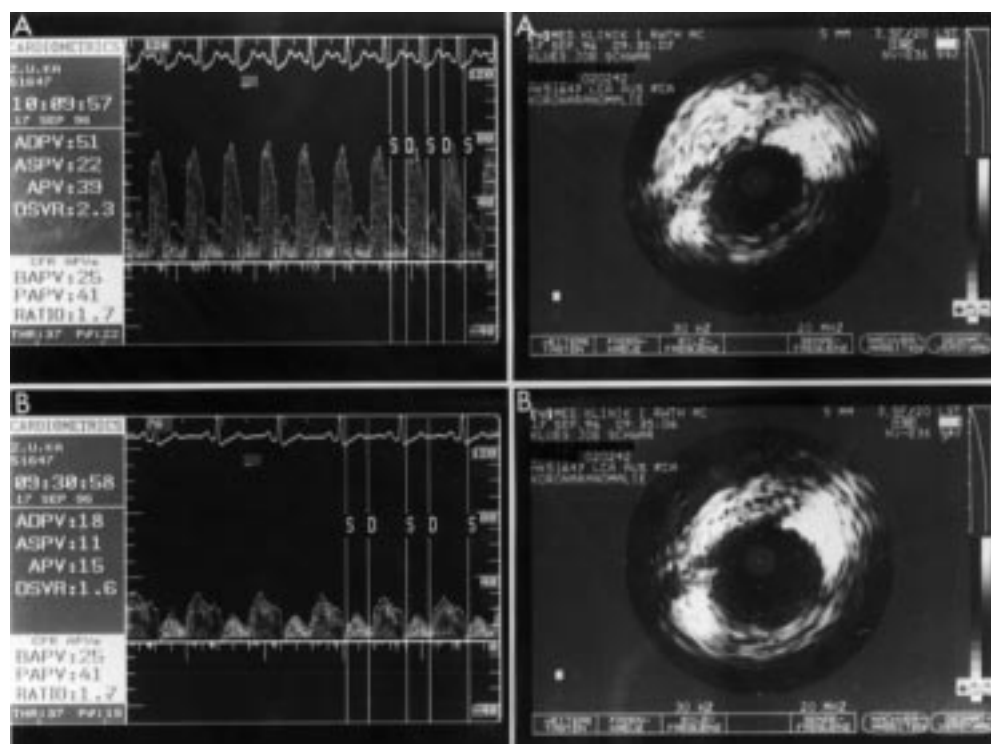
Intracoronary blood flow velocities (left) and intravascular ultrasound (right) within the left coronary artery at its sharp course dorsal the ascending aorta during dobutamine stimulation (A) and at rest (B). ADPV, average diastolic flow velocity; ASPV, average systolic flow velocity; APV, average peak flow velocity; DSVR, diastolic/systolic velocity ratio; BAPV, basic average peak flow velocity; PAPV, peak average peak flow velocity. RATIO, coronary flow reserve.
